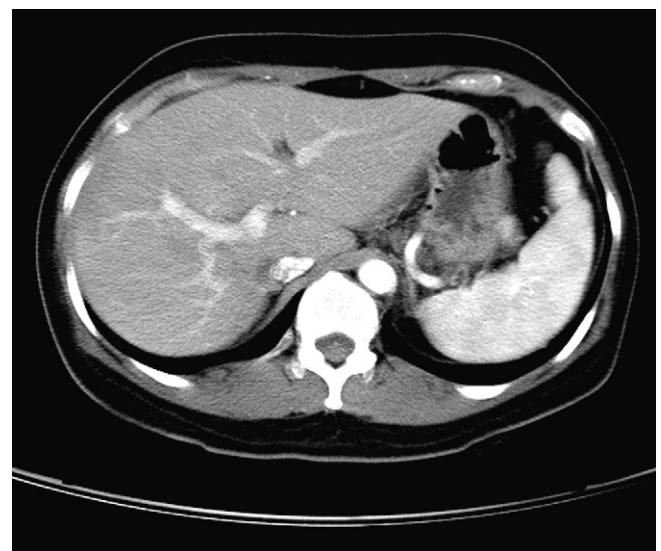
An enhanced CT scan of the liver 2 months postpartum shows no evidence of hepatic infarction with complete recovery.
